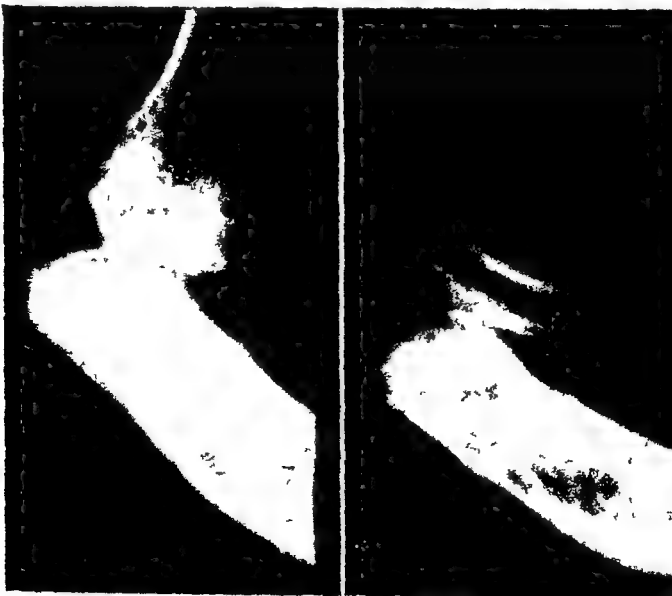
X-ray of the Knees of the preceding figure
